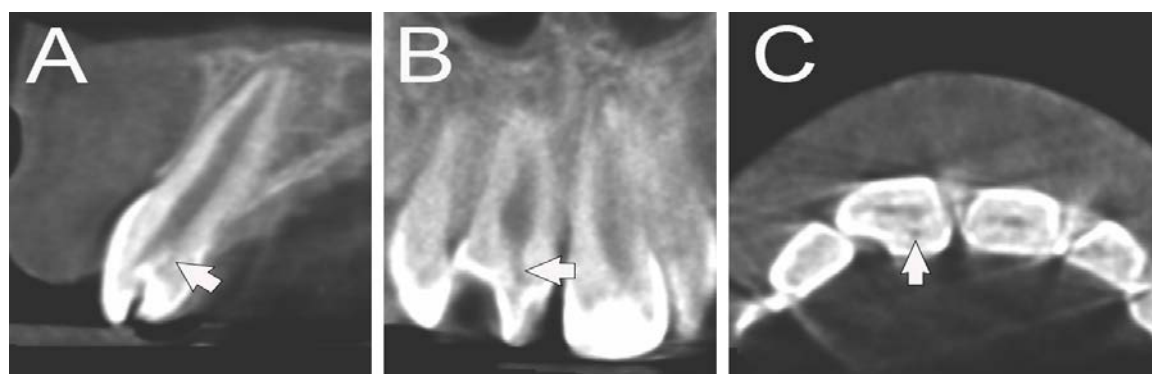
Cone-beam computed tomography images of the right maxillary central incisor: labiopapatal longitudinal section (A), mesiodistal longitudinal section (B), horizontal section of the crown (C). Arrows indicate a narrow extension of the pulp tissue from the pulp chamber into the cusp.
